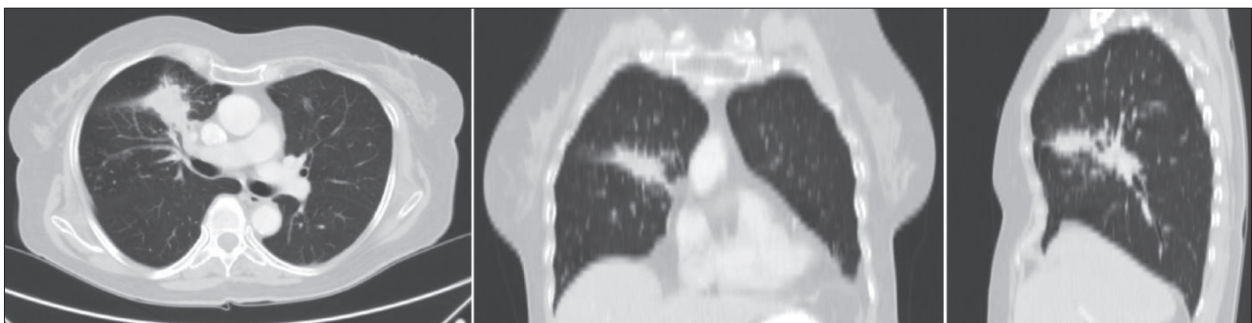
Chest CT at the time of disease progression to the drug afatinib
